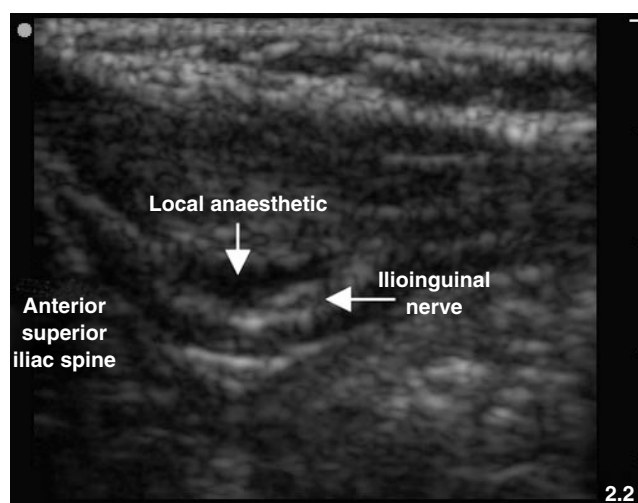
Ultrasonographic view of the ilioinguinal nerve surrounded by 1.2 ml of local anaesthetic.
